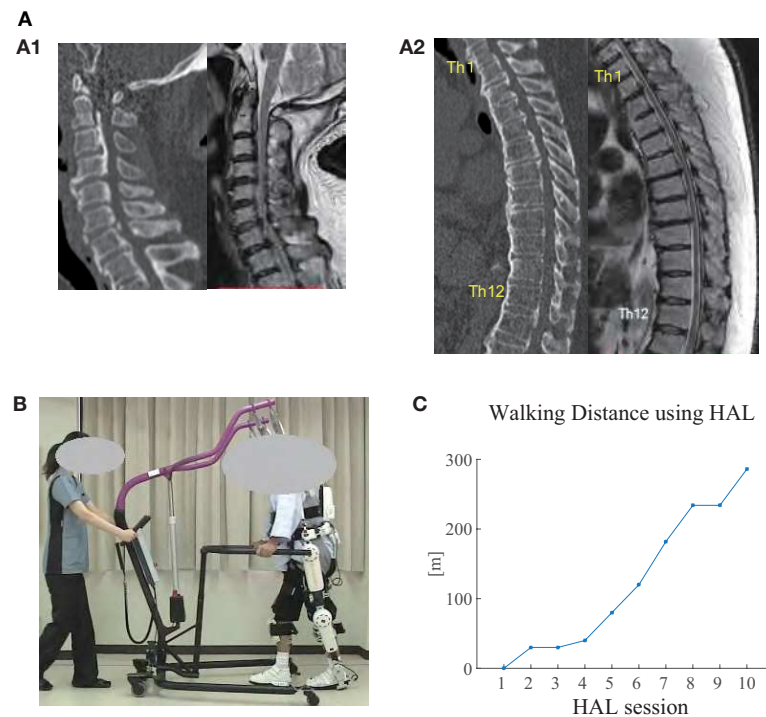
(A) CT (left) and MRI (right) images of the cervical spine (A1) and thoracic spine (A2) before surgery. Ossification of posterior longitudinal ligament (OPLL) was observed in the cervical and thoracic spine (from C2 to L1), where the spinal cord was being compressed. Diffuse idiopathic skeletal hyperostosis (DISH) was also observed from C4 to L2. Herniated disc was observed at Th8/9. (B) The patient walking overground using Hybrid Assistive Limb (HAL) in the seventh HAL session. An All-in-One Walking Trainer device was also used to provide weight support and for safety. An assistant pulled the device in accordance with the patient's gait. (C) Walking distance using HAL in each session. The distance gradually increased through the sessions.
